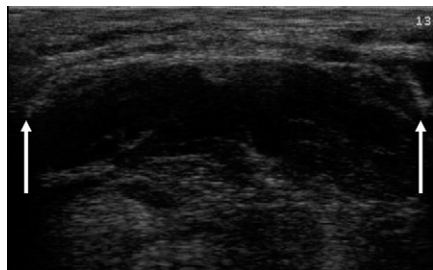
Transversal ultrasonographic section of the basis of the tongue. The tongue is presented as a muscular organ with typical hypo(-iso)echogenic ultrasonographic structure; on both sides of the base, palatopharyngeal folds are clearly visualized (arrows).
